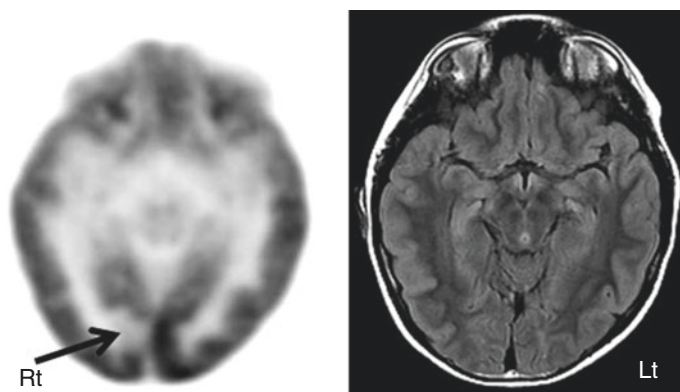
2-Deoxy-2(^{18}F)-fluoro-D-glucose PET (*left image*) in a child with intractable epilepsy, normal fluid-attenuated inversion recovery (FLAIR) MRI (*right image*), and bilateral synchrony on EEG showed a very focal area of hypometabolism (*arrow*), which is strongly suspected to be cortical dysplasia
